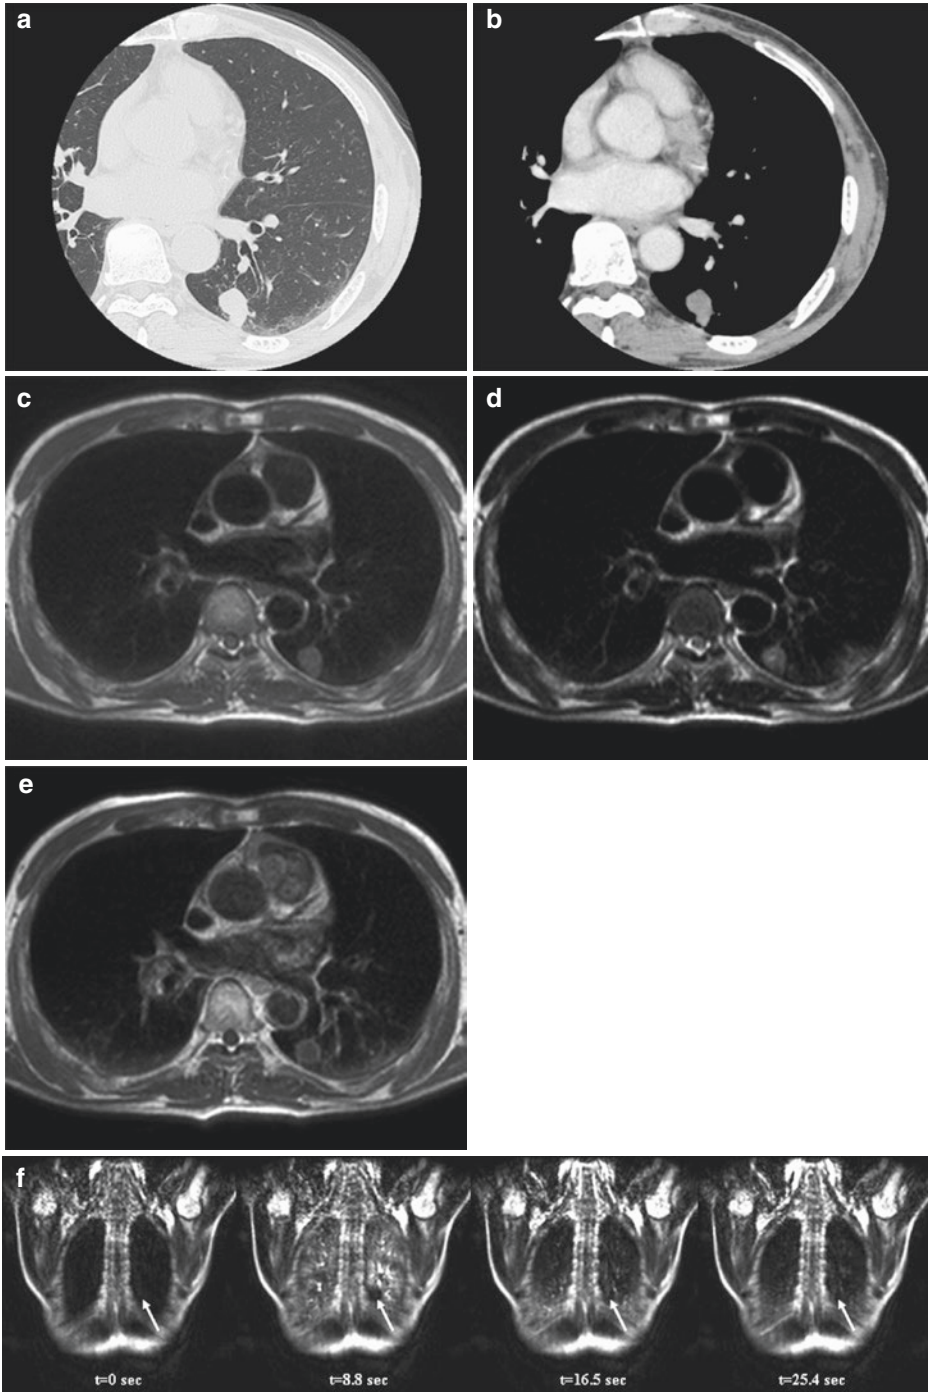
A 67-year-old male with tuberculoma in the left lower lobe. Thin-section CT shows a solid nodule in the left lower lobe (a). Contrast-enhanced CT indicates homogeneity but little enhancement within the nodule (b). Black-blood T1-weighted turbo SE (c) and T2-weighted turbo SE (d) images show the nodule as, respectively, low and intermediate signal intensities in the left lower lobe. Post-contrast black-blood T1-weighted turbo SE image
